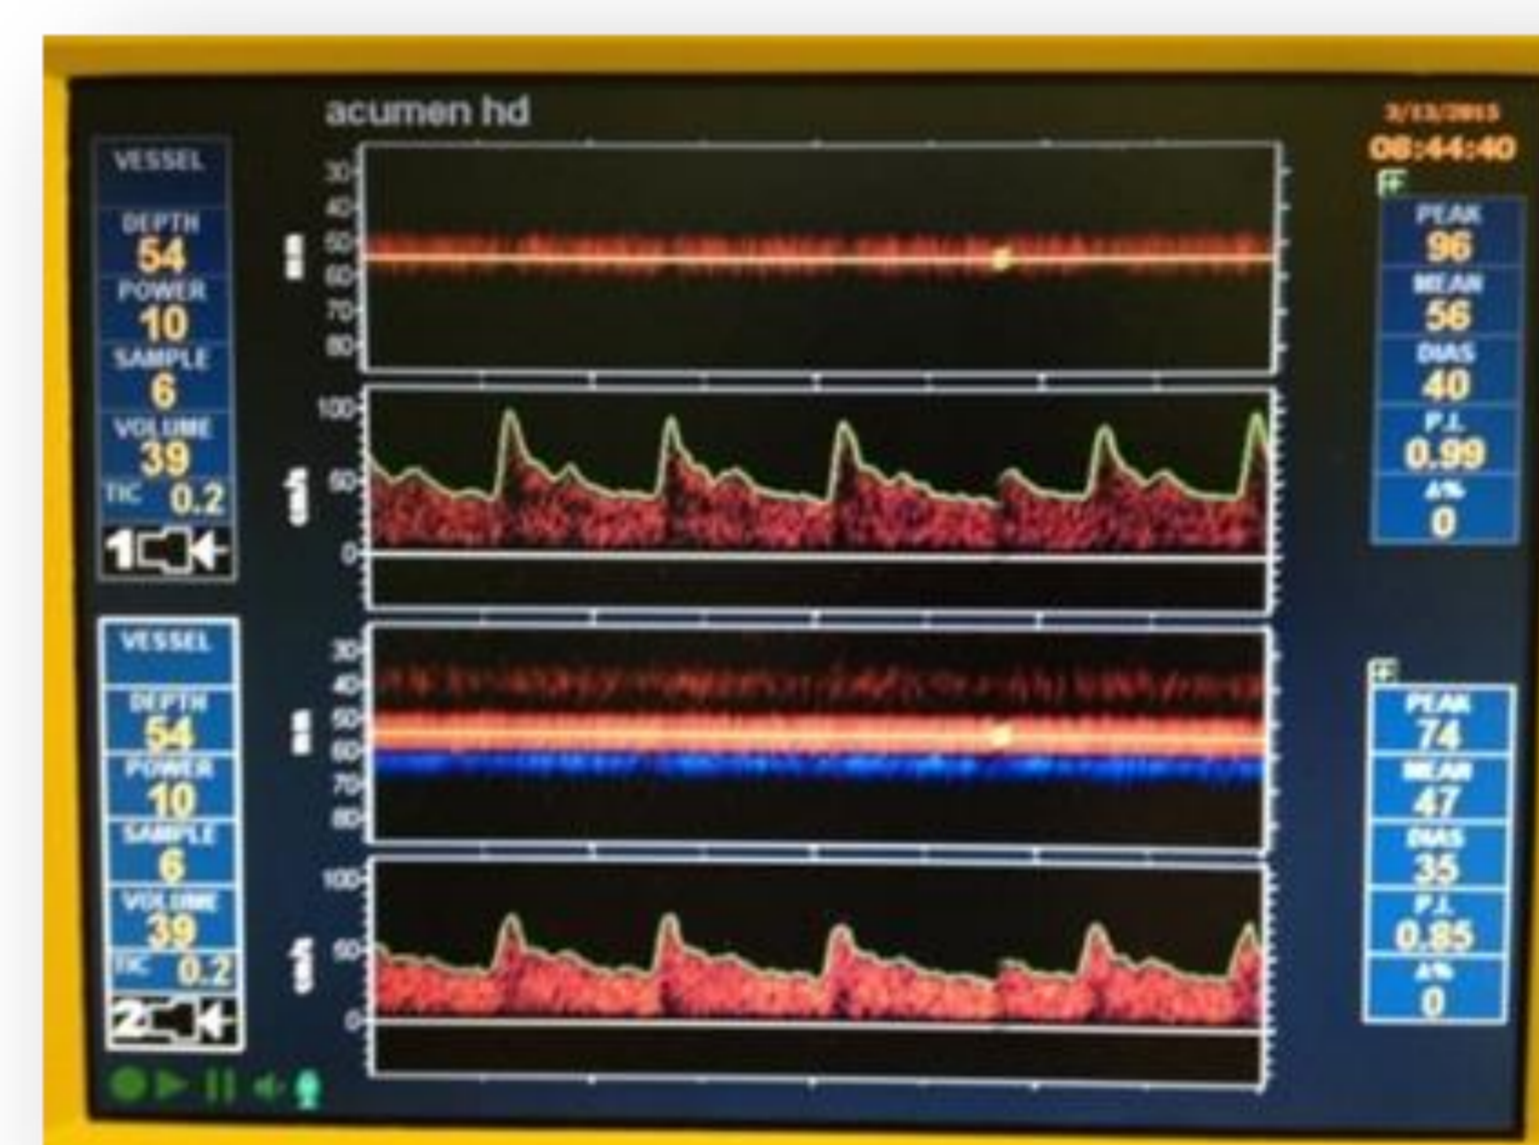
Screen shot of transcranial doppler unit demonstrating bilateral insonation of middle cerebral arteries
